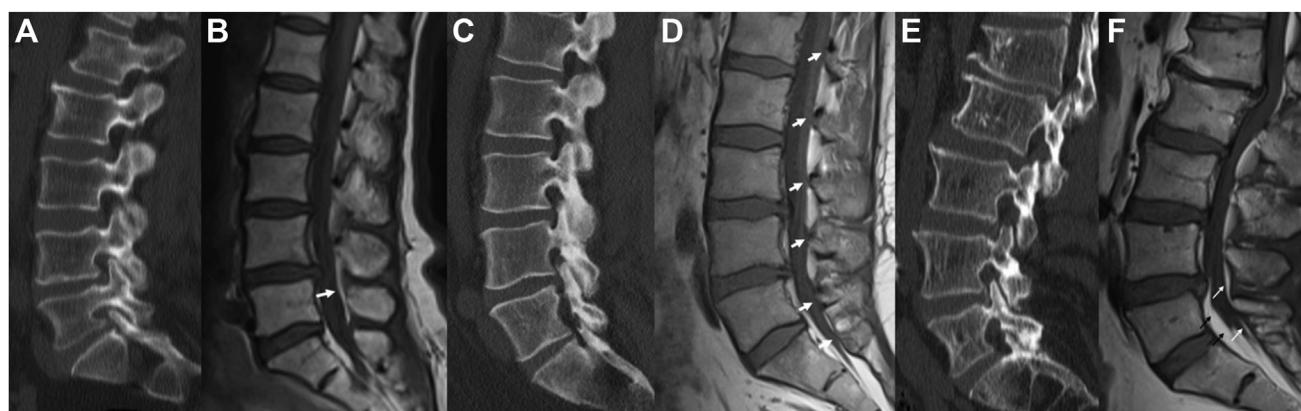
(A) The 25th patient with DDD had intact pars at L5 on lumbar CT and (B) positive EFI on lumbar T1-W MRI (arrow). (C) The 55th patient with DDD had intact pars at L5 on lumbar CT, normal epidural fat tissues, and (D)
